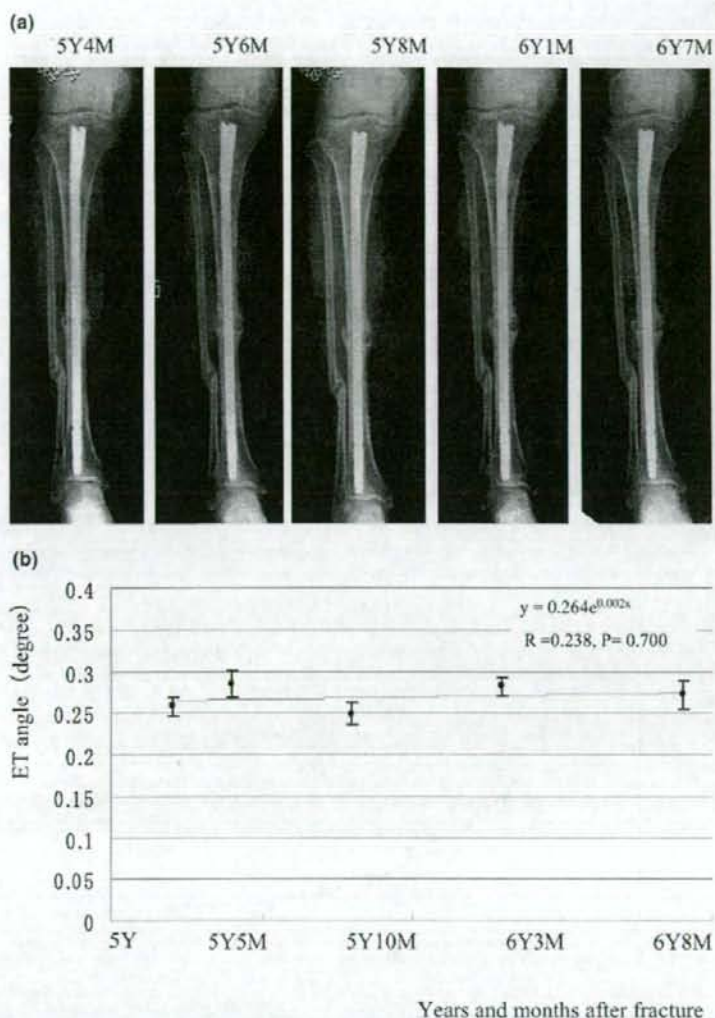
(a) Time sequential change of the fracture site X-ray from 5 y 4 mo to 6 y 7 mo after fracture in case 7, treated with intramedullary nailing. The X-ray films showed hypertrophic nonunion, but judgment of whether healing was proceeding was extremely difficult. (b) In case 7, the ET angle showed no change over time and the regression lines showed no significant decrease.
